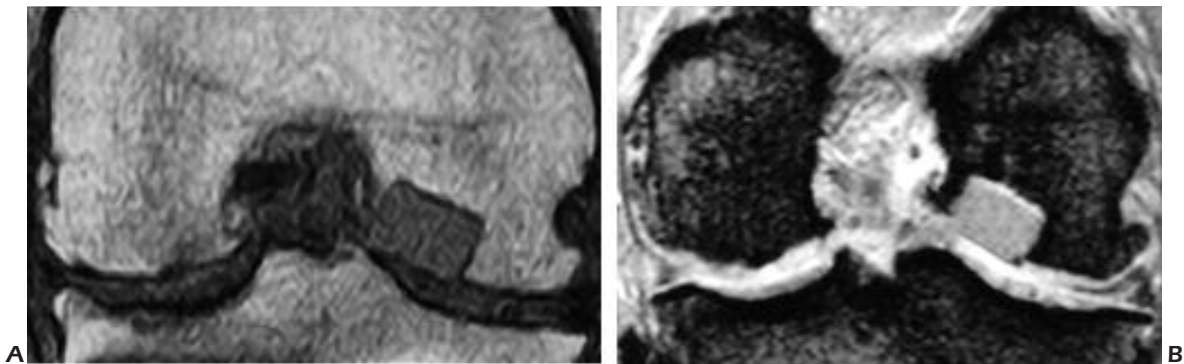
57 year old male with 10 mm IV degree cartilage defect on the weight bearing area of left medial femoral condyle. Patient is a competitive dancer and has been participating in global world class competitions for 13 years. a. & b. MRI at 6 and at 54 months show no modification of the implant position. No adverse events to date. IKDC: from 28.73 pre-op to 94.25 at 54 months post-op.
